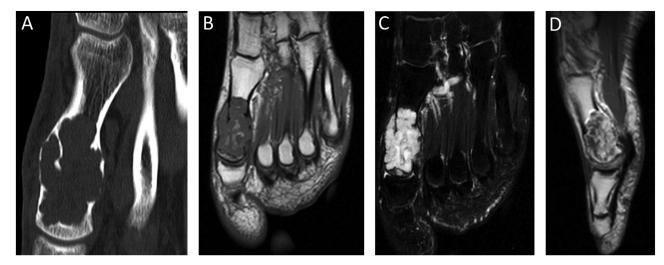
CT (A) shows a lytic lesion in the distal diaphysis and head of the first metatarsal that causes bone cortical expansion. It has intermediate signal on T1WI (B), hyperintense signal on STIR (C), with heterogeneous enhancement on T1WI (D) after administration of intravenous contrast. Anatomopathology (not shown) was compatible with chondromyxoid fibroma.
